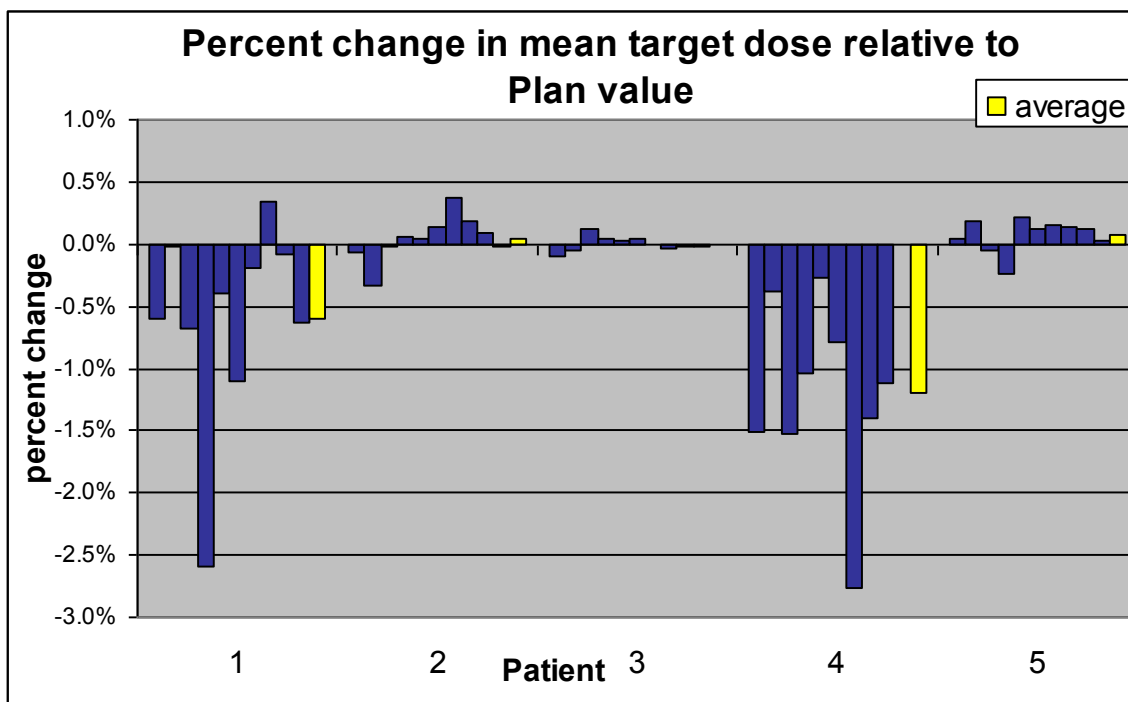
Change in mean target dose relative to the plan value for each patient. Each column represents data from one selected daily cone beam scan per consecutive week of treatment. The average for these values over the course of treatment is shown in yellow
